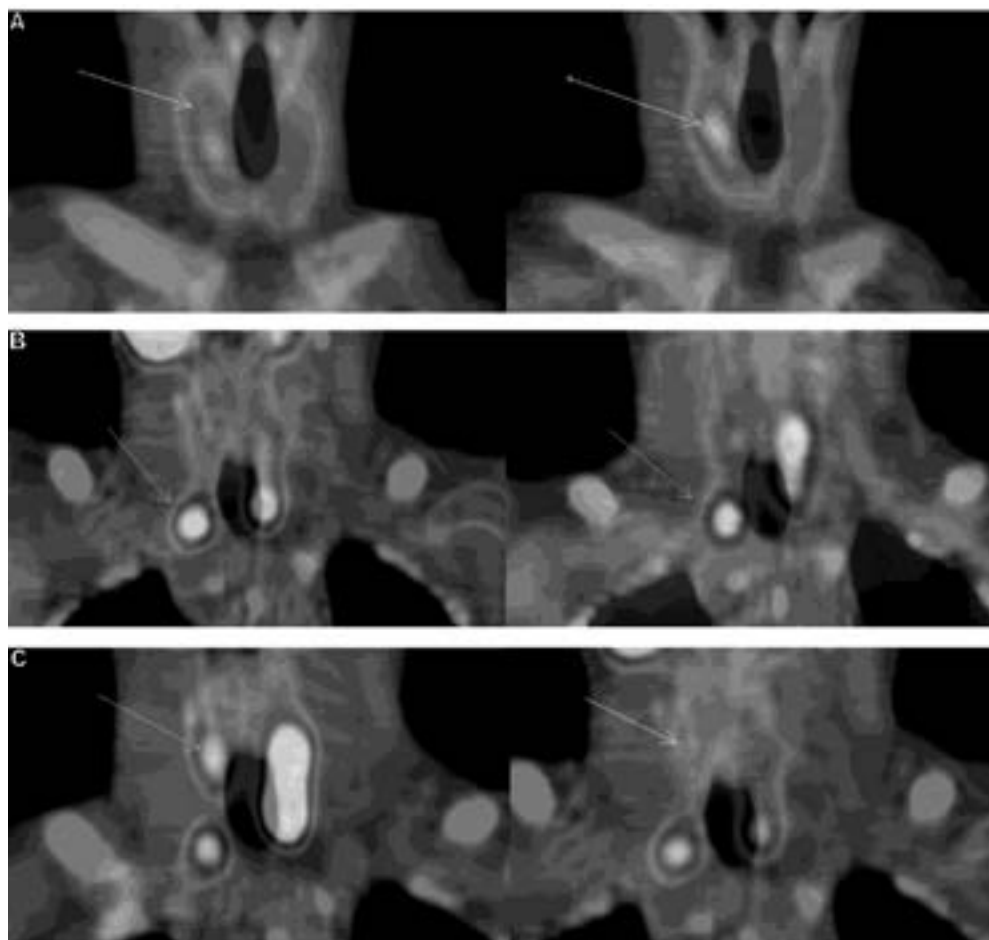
Three types of ^{99m}Tc -sestamibi SPECT/CT uptake in fusion coronal cross-sections; A. Type I — the tracer is visible in the delayed phase for right upper parathyroid gland. HP proved as adenoma (patient ZG, 56 y.o.); B. Type II — tracer is visible in both phases for right lower parathyroid gland. HP proved as adenoma (patient LM, 57 y.o.); C. Type III — the tracer is visible in the early phase for right upper parathyroid gland HP proved as NPT (patient LM, 57 y.o.). White arrows show lesions with or without uptake in corresponding phases of SPECT/CT PPS
